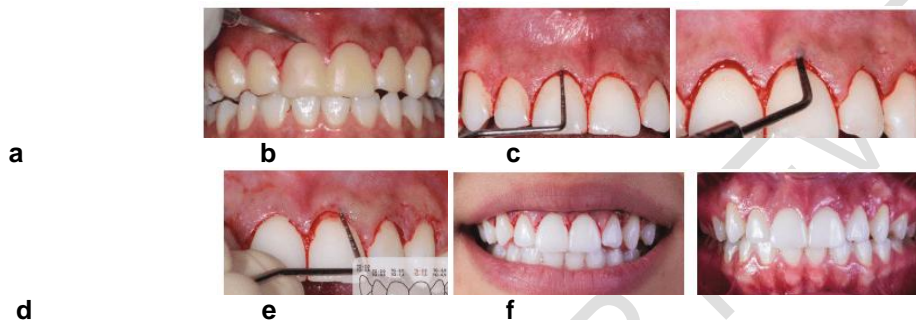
(a) Initial incision guided by mockup for elimination of gingival tissue.(b) Upon examining with a probe, confirmation of the 1mm distance between the gingival margin to the upper most part of the bone crest, indicating the necessity for osteotomy.(c) Utilization of piezoelectric ultrasound for osteotomy without flap elevation, ensuring no interference with interdental papillae.(d) Eliminating 1mm of bone to reinstate the biological width.(e) Immediate postoperative phase.(f) Follow-up after 6 months displaying the fully healed periodontal tissue [23].
